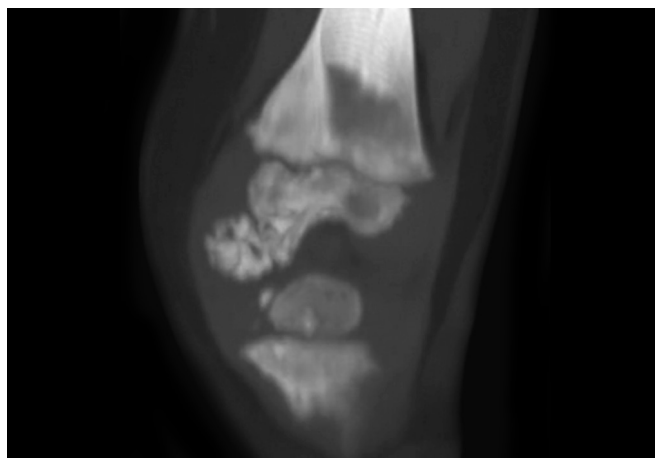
CT scan of knee joint showing half epiphyseal involvement characteristic of Trevor's disease.
